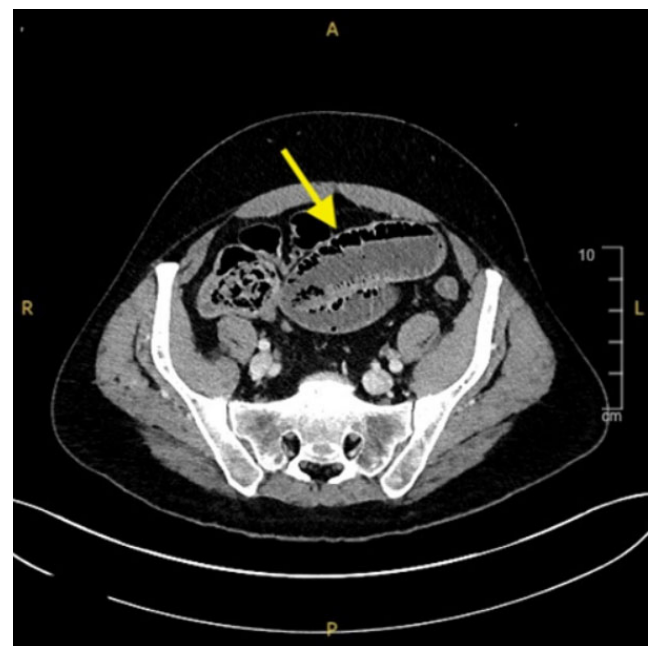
CT of the abdomen and pelvis showing a loop of ischemic small bowel with fluid level.
